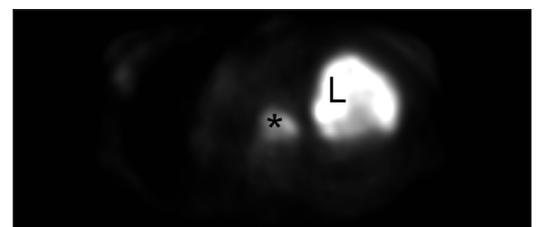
FDG-PET demonstrates intense uptake of the left atrial mass (*).
